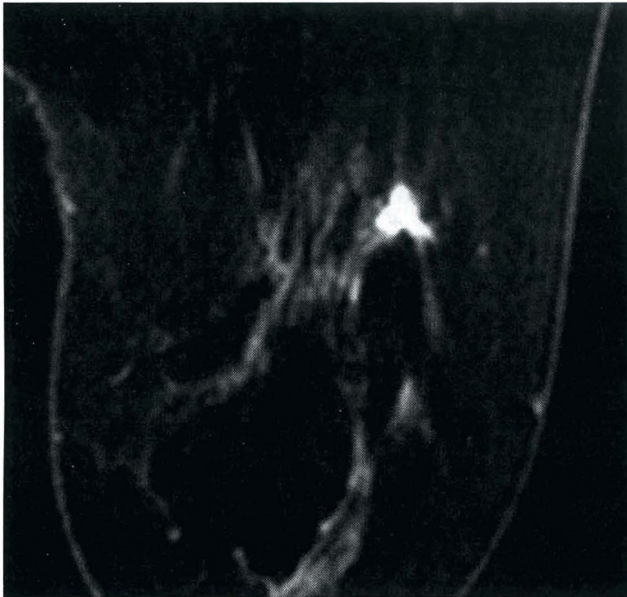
Breast MRI from a 53-year-old female whose sister was diagnosed with breast cancer at age 48. Although this was the only traditional risk factor for the patient, mammographic density was extreme, in and of itself an additional risk factor, as well as a predictor of low mammographic sensitivity. A 1.8-cm invasive ductal carcinoma, grade 1, node-negative, was identified on MRI screening.
